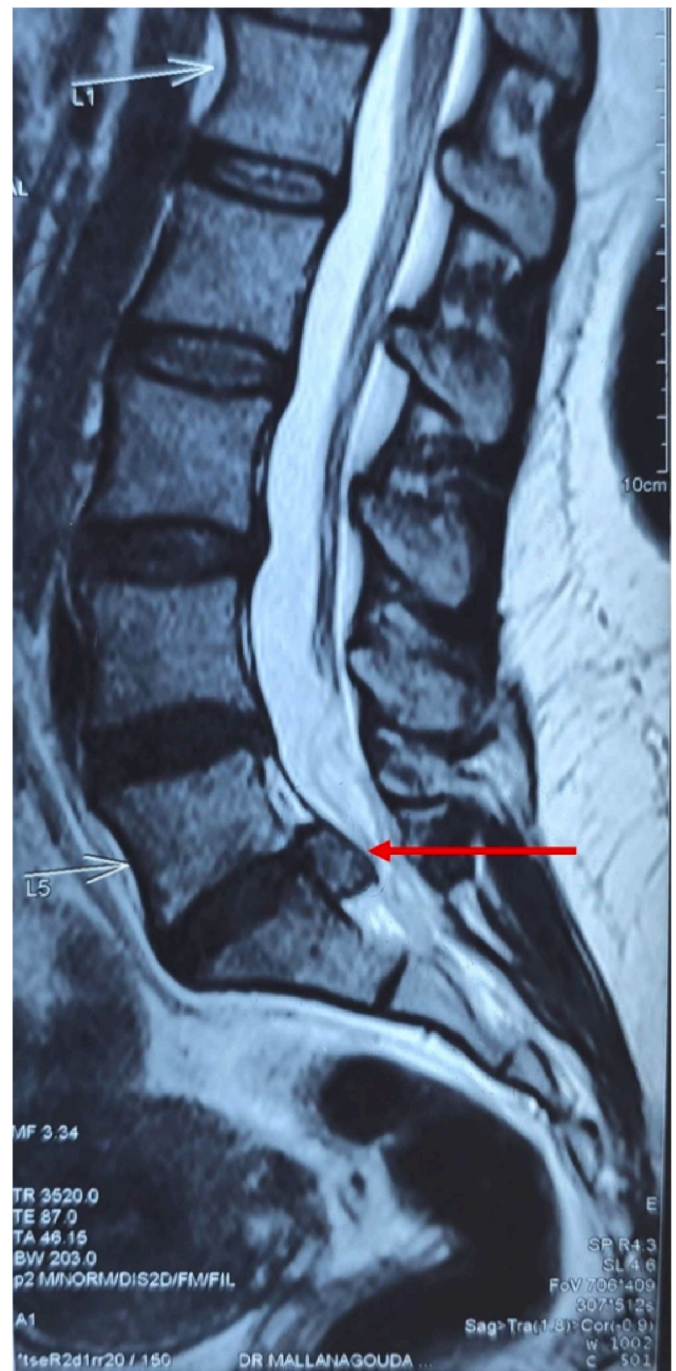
The red arrow in sagittal view of the T2-weighted image shows the extent of sequestered disc material in a caudal direction.
